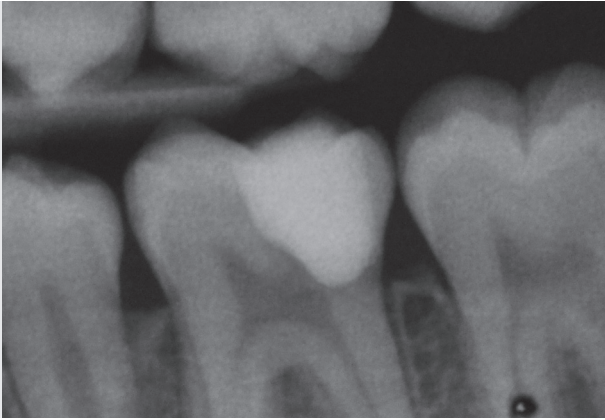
Postoperative X-ray: The distal enamel wall has been preserved.
